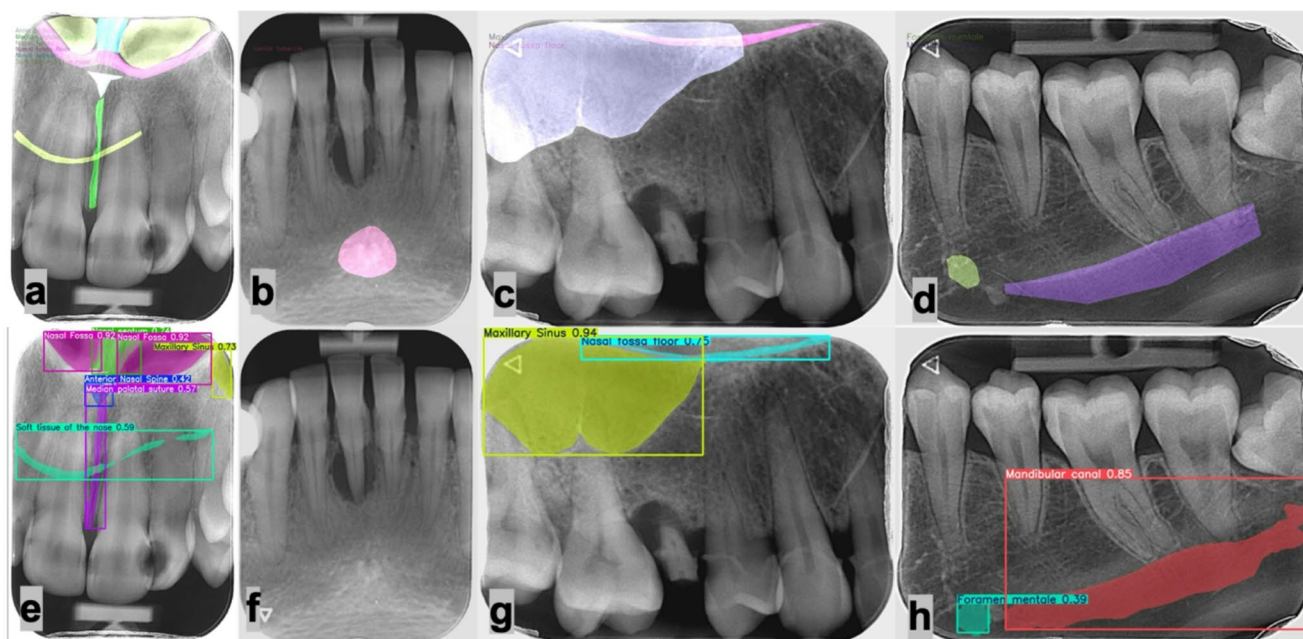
Representative examples of ground-truth annotations (top row) and corresponding model predictions (bottom row) on periapical radiographs. Panels depict anterior maxilla (a/e), mandibular anterior (b/f), maxillary posterior (c/g), and mandibular posterior (d/h) regions.
